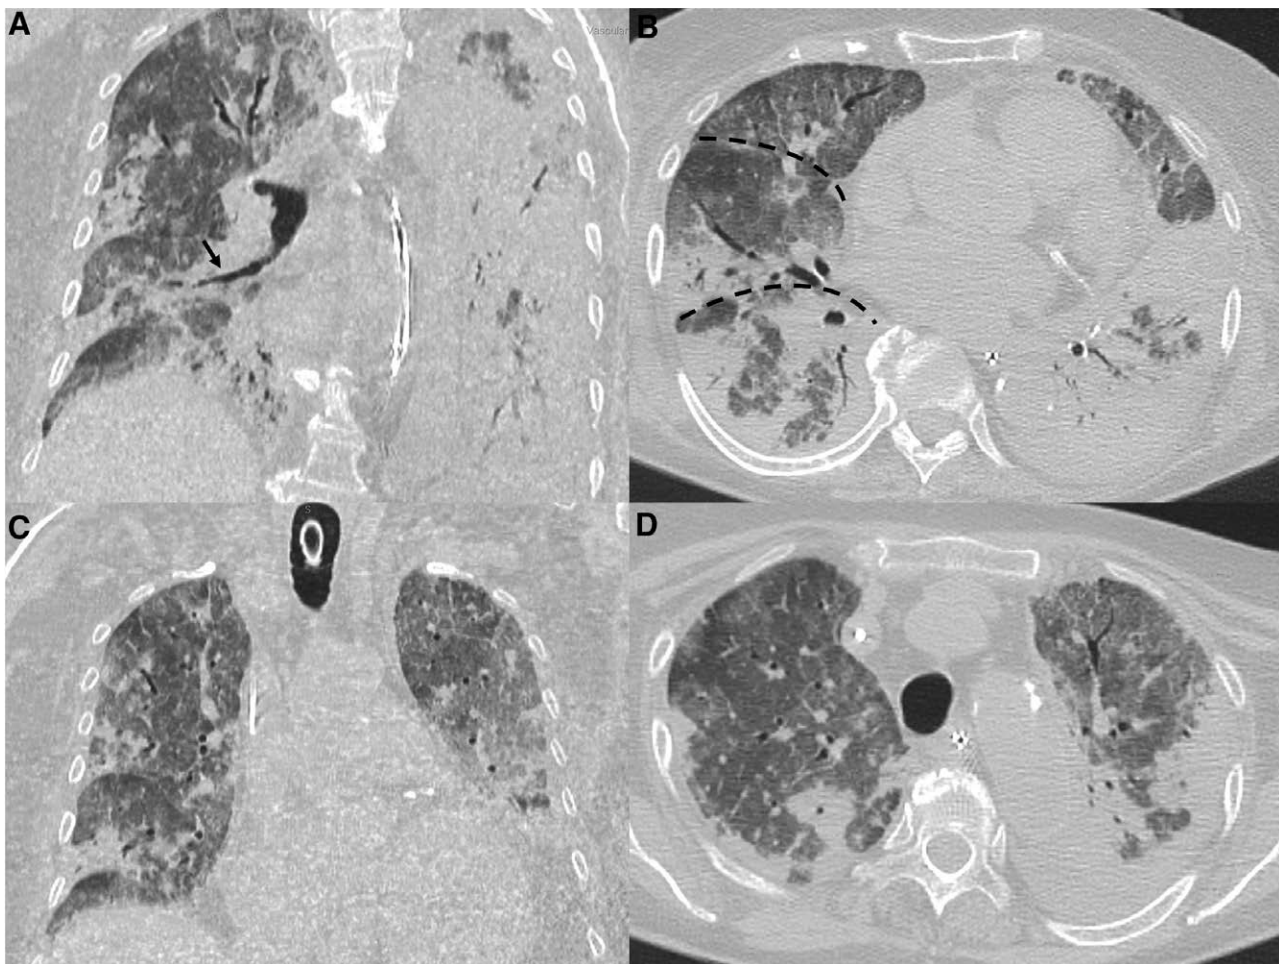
Extensive parenchymal involvement of the lungs including the right middle lobe. (A) Oblique coronal CT reconstruction focused on the right middle bronchus (black arrow) demonstrating its small diameter, length, and acute take-off angle. (B) Oblique axial CT reconstruction at the level of the right fissures of the right middle lobe (dashed black lines). (C and D) Coronal and axial CT reconstructions at the level of the superior vena cava and aortic arch respectively, showing bilateral extensive consolidation of lung parenchyma.
